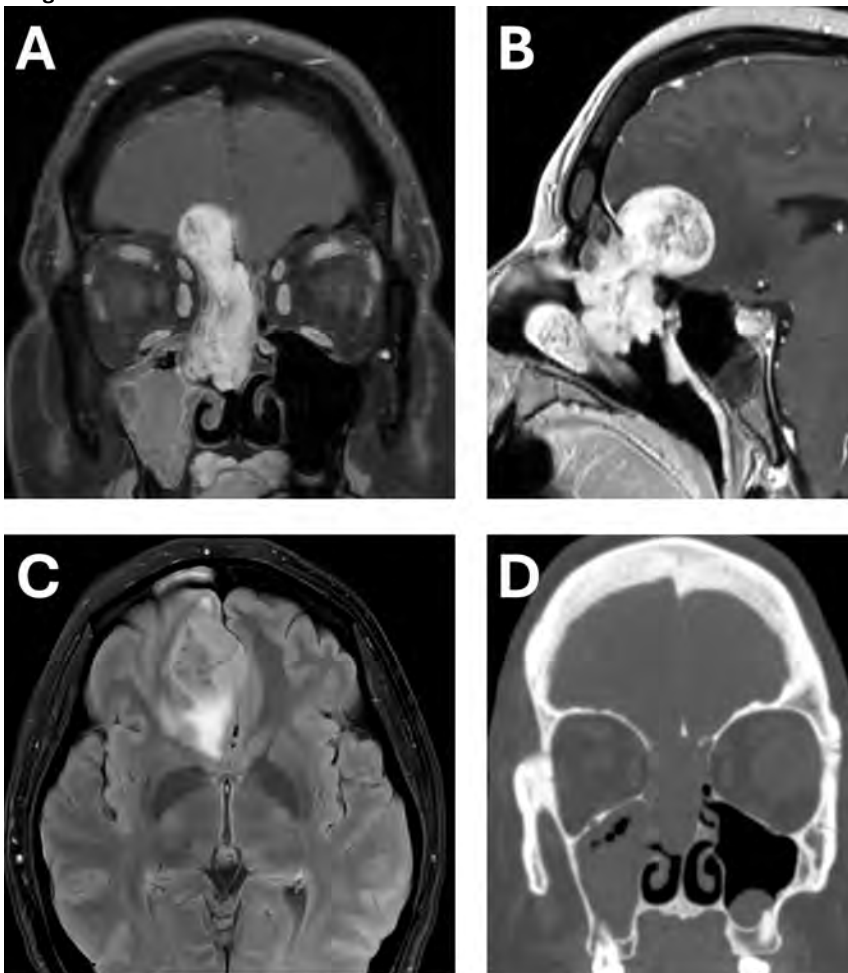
Post-contrast T1-weighted coronal MRI through the anterior skull (A) and reformatted sagittal 3D spoiled gradient recall imaging (B) reveal a large, lobulated sinonasal mass with intracranial invasion. T2-FLAIR MRI (C) highlights the mass's heterogeneous T2 signal and the vasogenic edema indicating brain invasion. Coronal CT (D) highlights bone loss with bone remodeling around the lesion rather than aggressive erosion.
